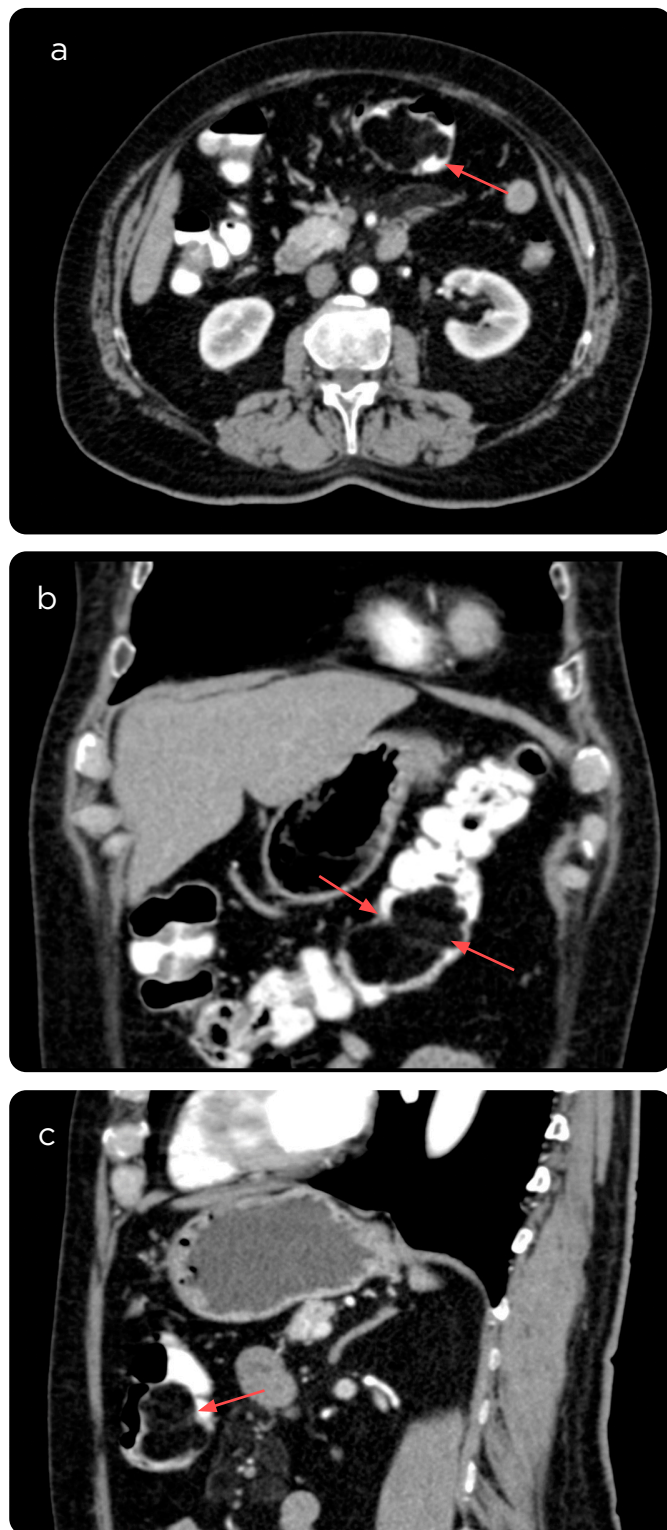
Abdominal CT with oral and intravenous contrast medium. a) soft tissue algorithm in axial section, b) coronal and c) sagittal reconstructions. Low density mass, with well-defined borders (red arrow), with typical fat density (-100 HU). It is located in the transverse colon. It has no signs of intestinal obstruction, wall invasion or extramural involvement. It is compatible with colon lipoma.
